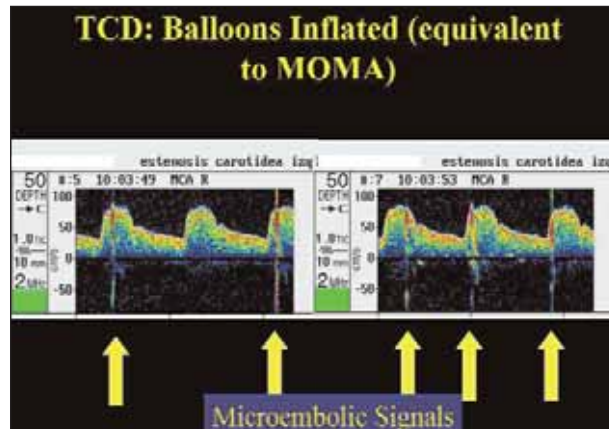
Transcranial Doppler image during CAS with proximal occlusion without reversal of flow shows presence of HITS.
